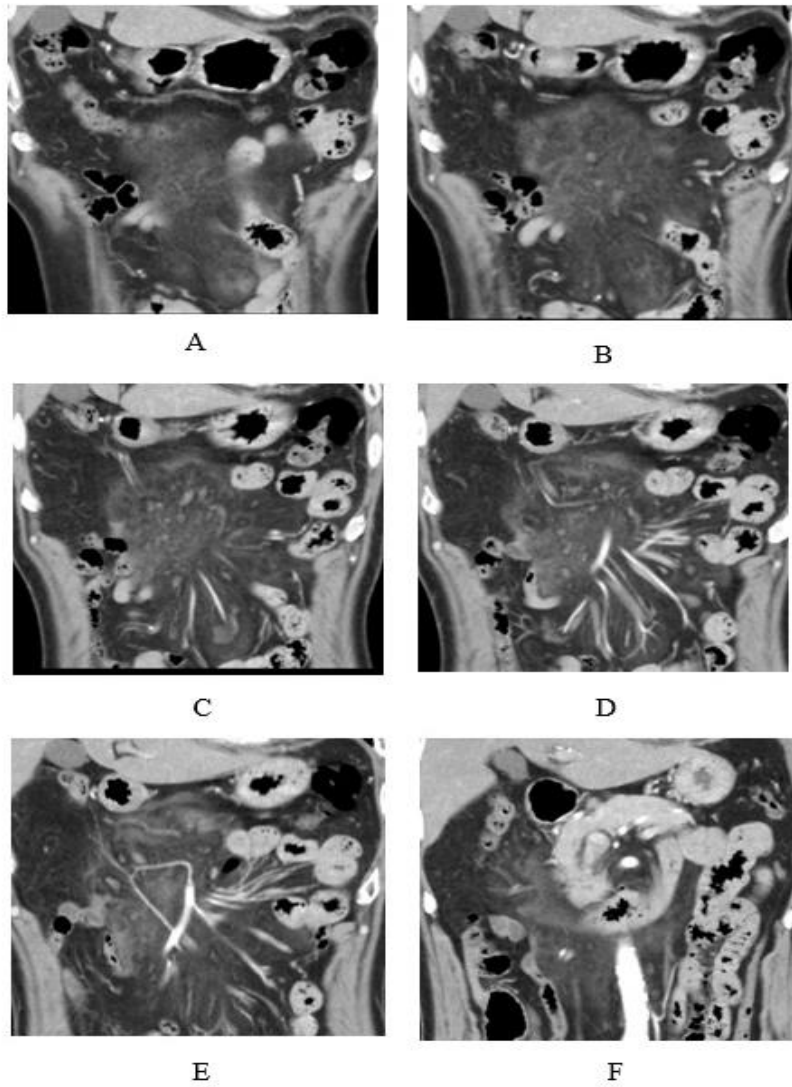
Fat dirty sign is demonstrated in fat tissue below transverse colon (A), along with middle colic artery (D, E), and between transverse colon and pancreas head (A-F) is visualized on contrast-enhanced abdomen CT.
